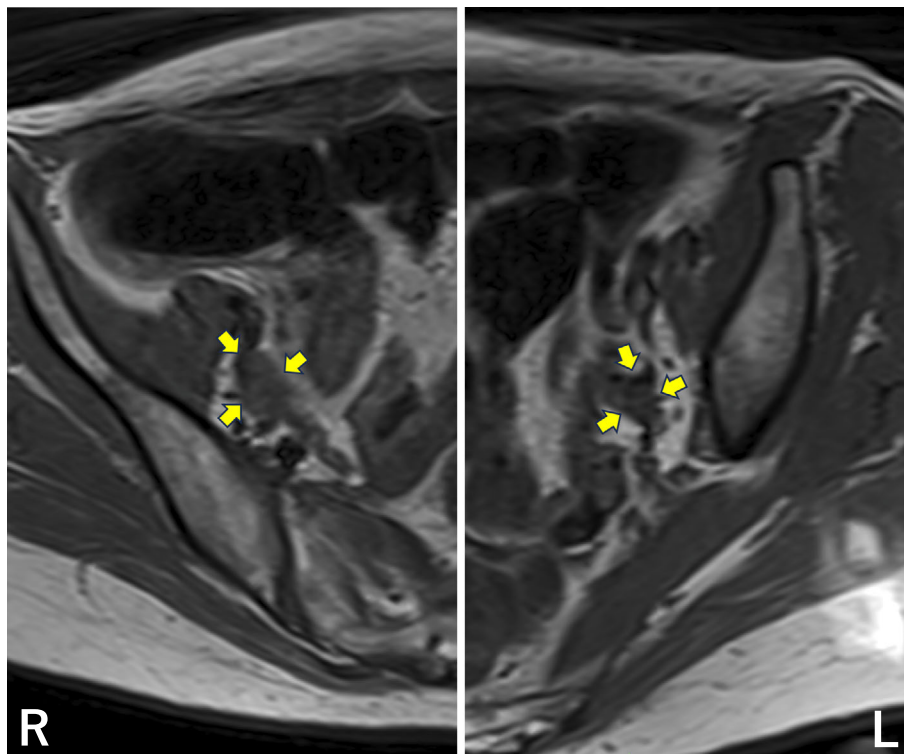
Magnetic resonance imaging in the pelvis (T2-weighted imaging). The bilateral ovaries were atrophic (arrows). No obvious pelvic masses were observed.
